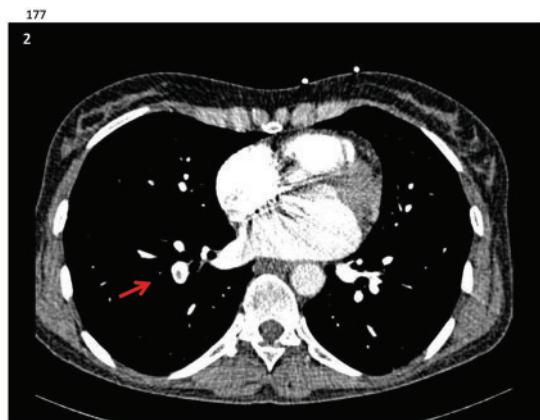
Computed tomography scan showing pulmonary embolism. Red arrow pointing at the pulmonary embolism.
